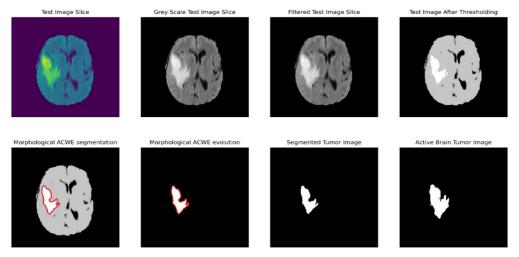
Segmentation of tumor area from a test MRI image.
